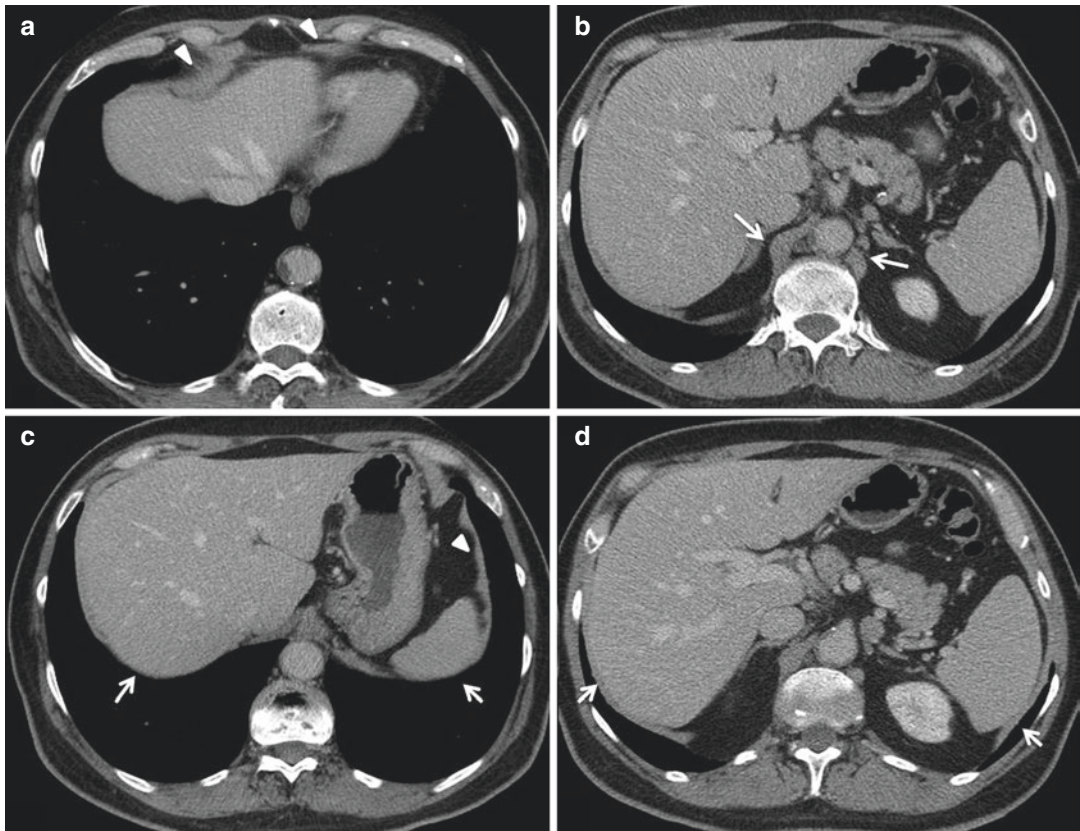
Normal CT anatomy of the anterior, posterior, and lateral/costal part of the diaphragm. (a, b) Axial MDCT images show the anterior diaphragmatic component (arrowheads) and the crura (arrows). (c, d) Axial MDCT scans of the lateral/costal part of the diaphragm
